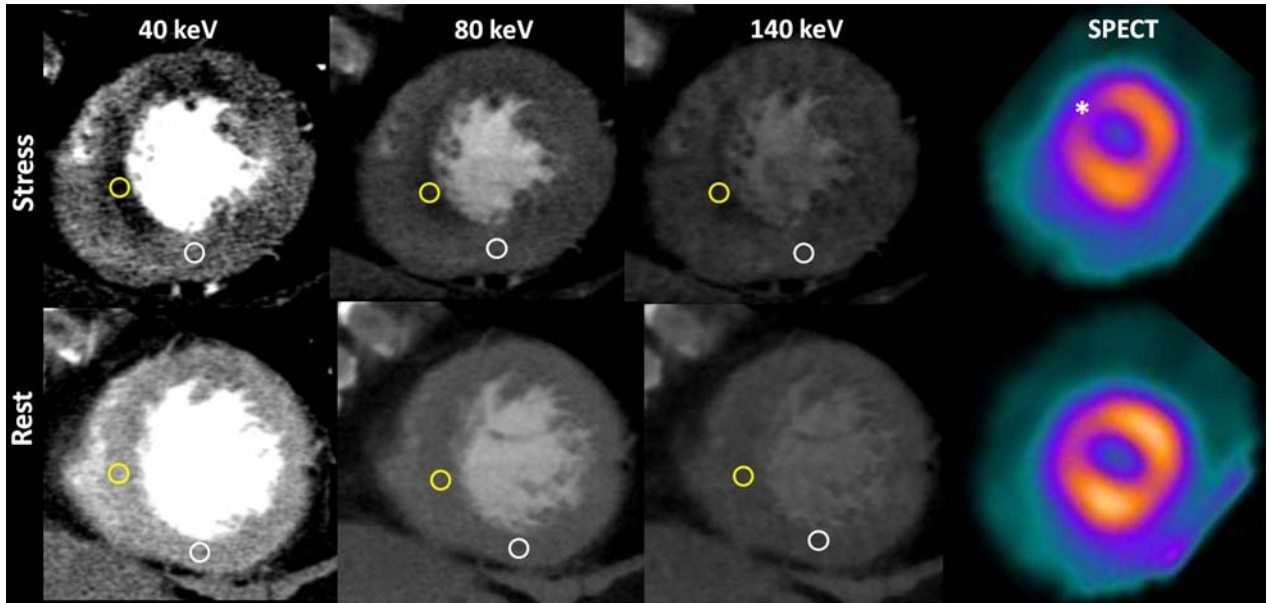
A 56-year-old male, former smoker, with effort angina. Heart rate at stress was 76 beats per minute, and heart rate at rest was 66 beats per minute. Presence of a reversible perfusion defect at the anterior and septal apical left ventricular wall (yellow). White regions of interests (ROIs) correspond to segment 15, where signal densities at stress/rest were 184 HU/215 HU (40 keV), 67 HU/84 HU (80 keV), and 43 HU/58 HU (140 keV). Yellow ROIs correspond to segment 14, where signal densities at stress/rest were 66 HU/194 HU (40 keV), 51 HU/64 HU (80 keV), and 43 HU/37 HU (keV). The reversible perfusion defect (*) is confirmed at SPECT. Figure 1 can be viewed online in color at www.jcat.org.
